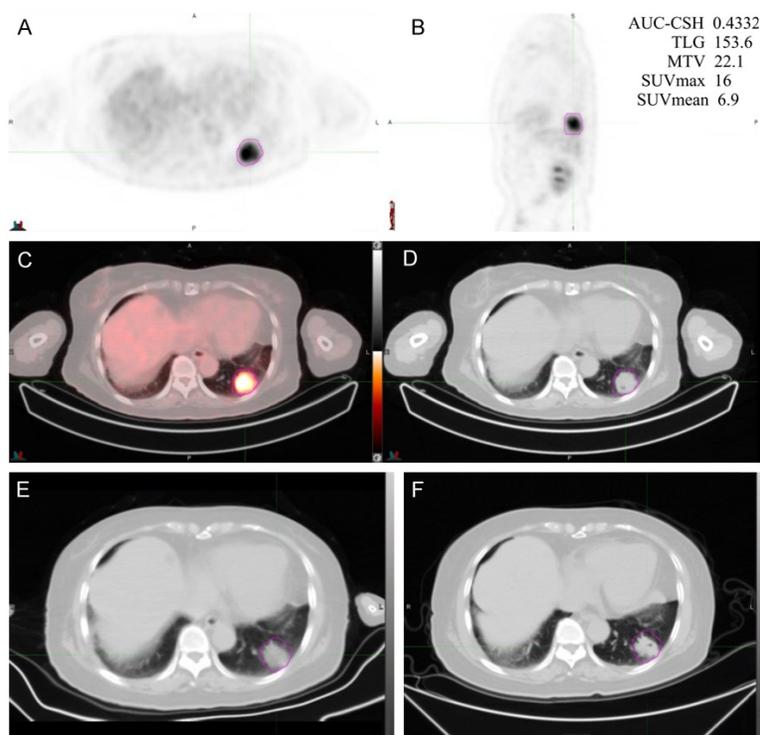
(A-D) ^{18}F -FDG PET/CT scan and MTV definition in a typical patient with a non-responding tumor. (A) Is a cross sectional PET imaging, (B) Is a sagittal PET imaging, (C) Is a fusion imaging of PET and CT, (D) Is a cross sectional CT imaging. (E, F) Pre-treatment and post-treatment association observed by CT imaging. (E) Is pre-treatment CT imaging and (F) is post-treatment CT imaging.
